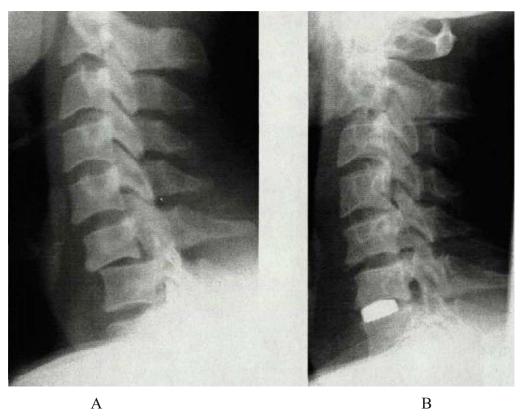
A- Radiograph of fracture-dislocation of the C6 vertebra. B - open reduction of fracture-dislocation of C6, discectomy, stabilization of the damaged segment with a porous nickel-titanium implant.
